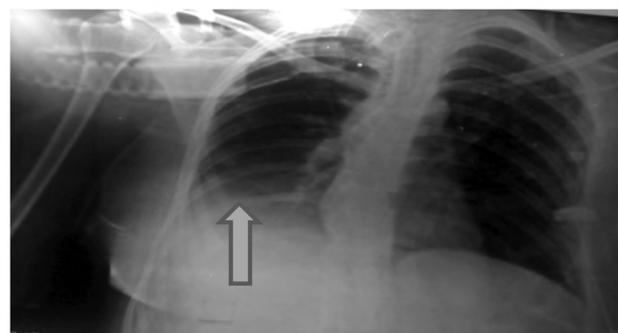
Chest X-ray infiltrate.
